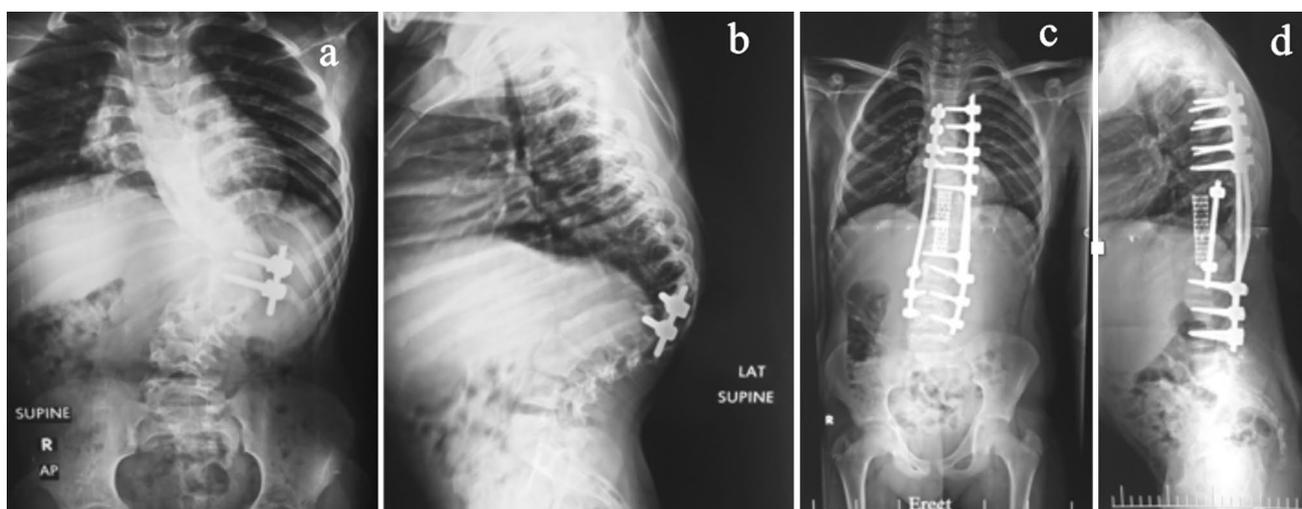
Male patient 12 years old with neglected congenital kyphoscoliosis with previous surgery for epiphysiodesis: a, b preoperative AP and lateral whole spine radiograph showing scoliosis measuring 86° and thoracolumbar kyphosis with LKA of 90° . c, d 1-year follow-up
